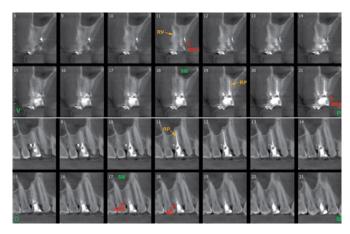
CBCT endodontic treatment follow-up (Mar/2015), showing, at the level of the cervical third in PR, with the endodontic material overfilling and spreading towards the external root wall, both palatally and distally. In sagittal and coronal slices, at the level of bone plates, which can be observed, both palatally and distally, in close proximity to the overfilled endodontic material.
